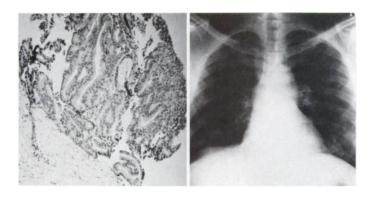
Initial chest radiograph, revealing multiple bilateral pulmonary nodules of varying size, consistent with metastases (left). Percutaneous pulmonary biopsy revealing moderately well-differentiated adenocarcinoma (center). Posterior and selected coned-down projections of Tc-99m MDP whole-body bone image, showing only degenerative changes (right).
